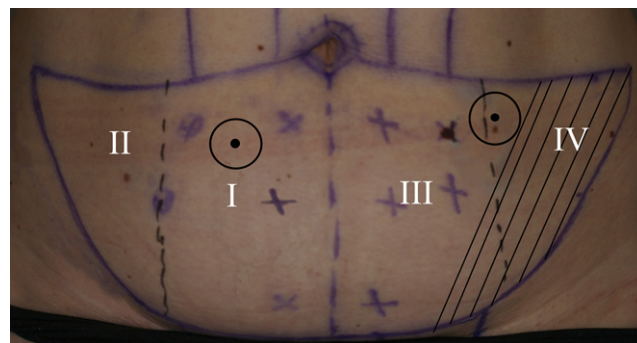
Zone classification and LDF measurement sites. I–IV = Blood flow zones. ⊙ = Laser Doppler flowmetry sites. Black dots in the centre of the circle represent the blood flow measurement sites in zones I and IV. Ipsilateral to the vascular pedicle, the LDF probe holder in zone I is sutured between the medial and lateral row of the perforators, whereas the second holder is sutured at the medial border in zone IV. The shaded area represents the part of the flap (zones III and IV) which is usually discarded. If needed, distal parts to the perforator vessels were also discarded in zone II and zone I. This method ensured a measurement location in zone I and zone IV.
